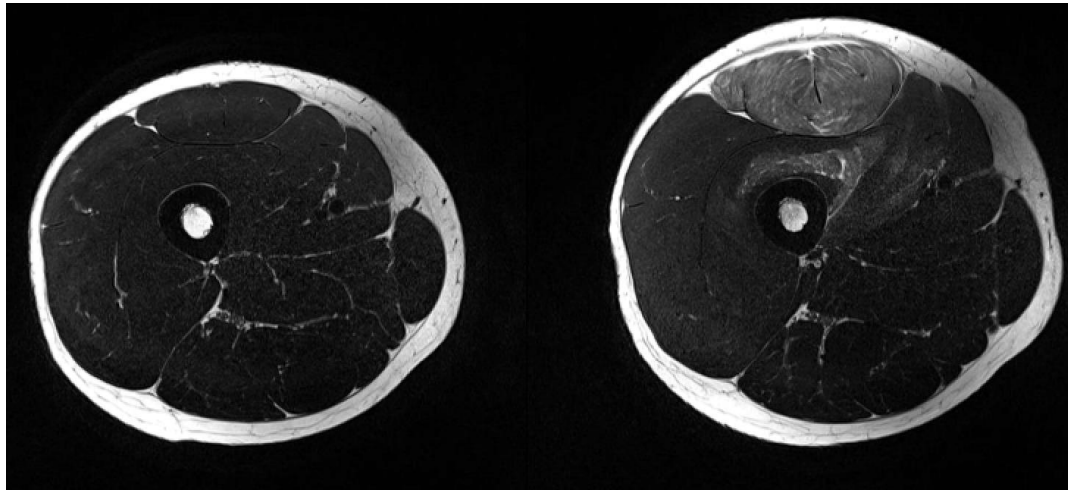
T2-weighted MRI scans obtained before (left) and 2 days after (right) the EIMD protocol in a participant who developed Oedema in the Rectus Femoris and Vastus Intermedius muscles of the Quadriceps.
